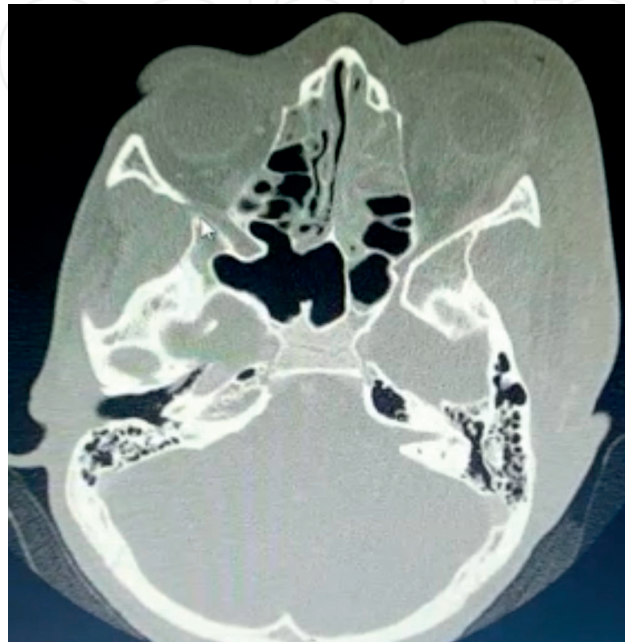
Left orbital cellulitis secondary to a left ethmoiditis with left periorbital oedema and associated mucosal thickening in the right ethmoid sinus (axial CT scan).
